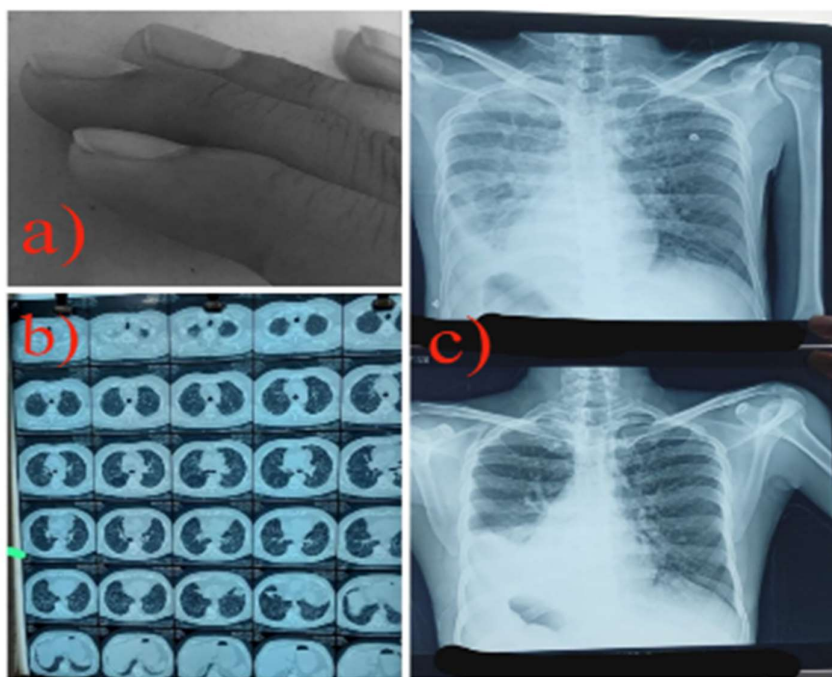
a) Digital Clubbing, b) HRCT, and c) Pre-post Chest X-ray Presentations
